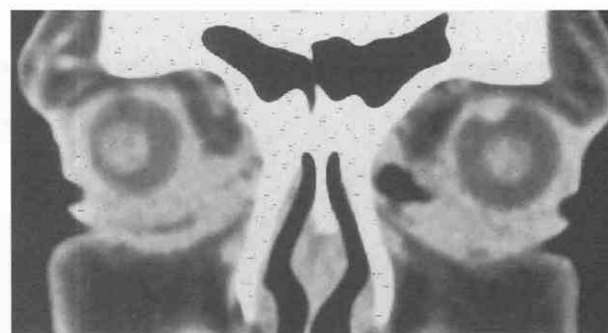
Axial contrast-enhanced CT scan shows prostate metastasis to the left orbit roof.
